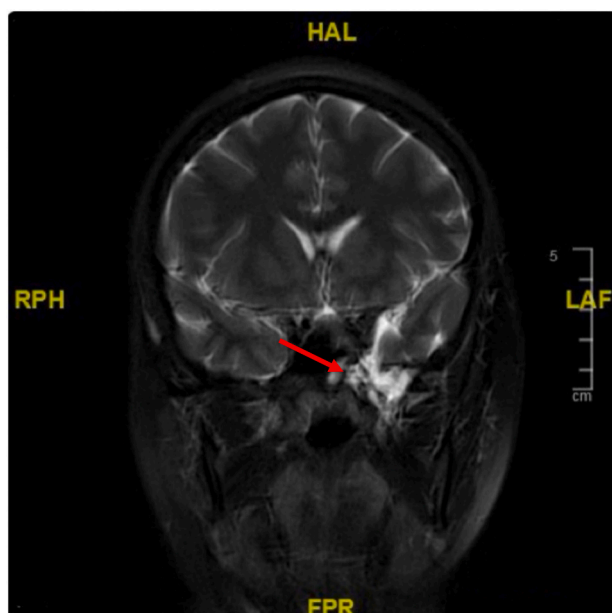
Postoperative T2W MRI Brain, Coronal section, showing inflammatory changes at the surgical bed with resolution of the meningocele.
